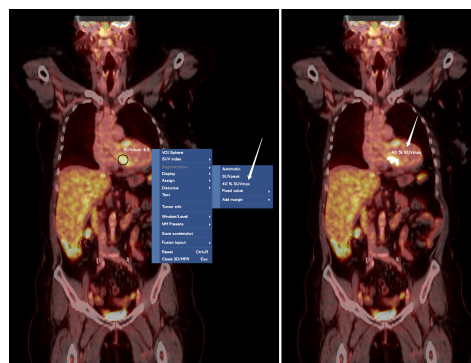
The user can select which segmentation method to use and in the image to the right the setting 40 % of SUV_{max} has been selected.
